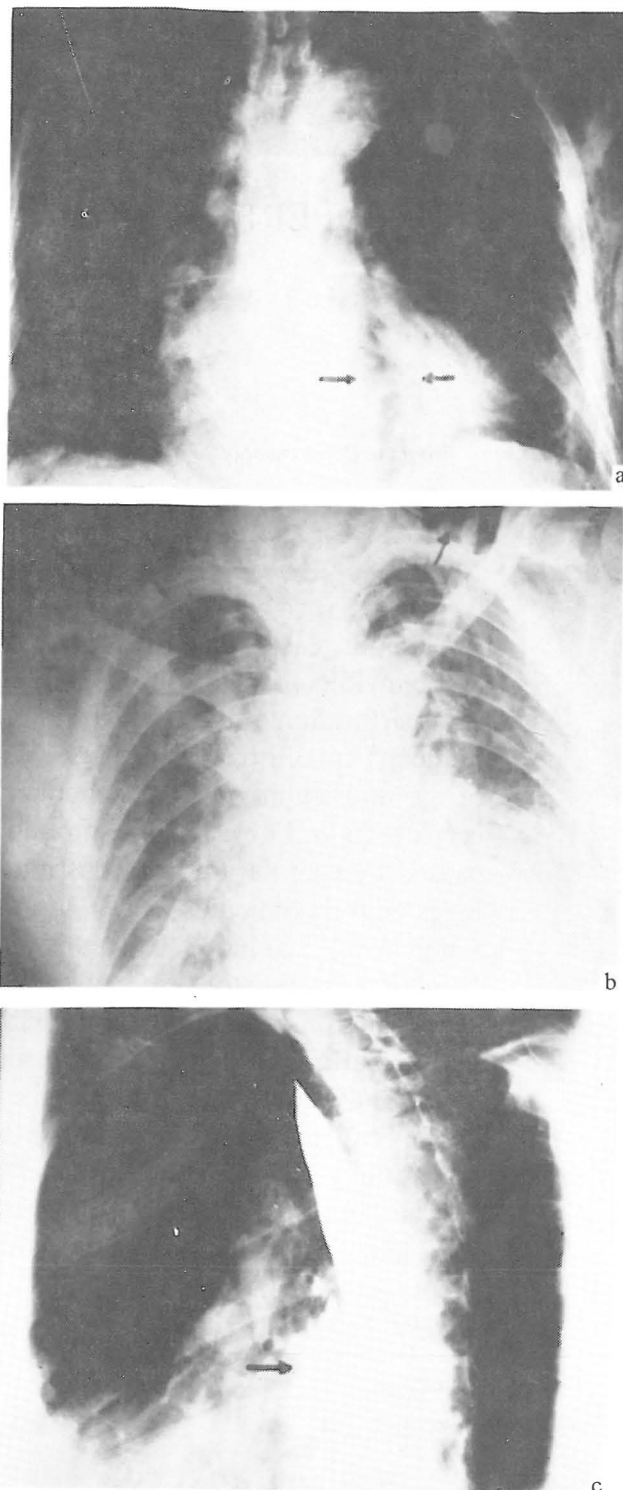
Spontaneous perforation of the esophagus. Roentgenographic studies of a 77 year old man who was admitted with sudden chest pain of 24 hours' duration. Note the widened mediastinum and pneumomediastinum (a), severe subcutaneous emphysema, radiolucent streaks of air at the base of the neck, chest wall, and mediastinum (b), and extravasation of radiopaque contrast material into the mediastinum (c).
